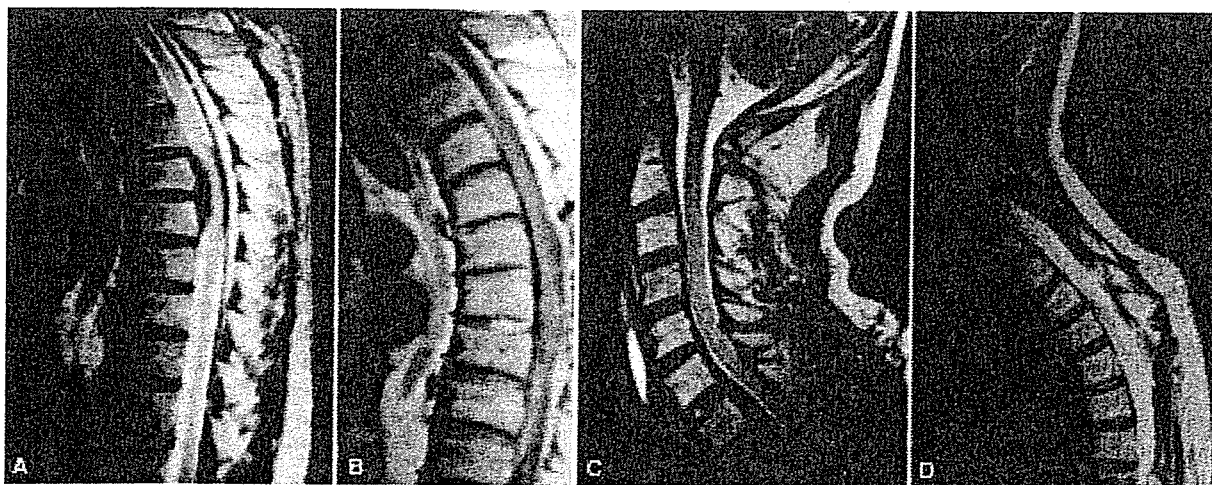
Case 1. Preoperative and postoperative MR images. A: Sagittal T<sub>2</sub>-weighted sequence obtained before the first operation, revealing dorsal and ventral T6–7 cord compression. B: Sagittal Gd-enhanced sequence obtained before the second operation, revealing HSP at the T3–5 level. C: Sagittal T<sub>2</sub>-weighted sequence obtained before the third operation, revealing thickened dura at C-6 to T-1. D: Sagittal T<sub>2</sub>-weighted sequence obtained after the third operation, revealing decompression of the entire lesion area.
